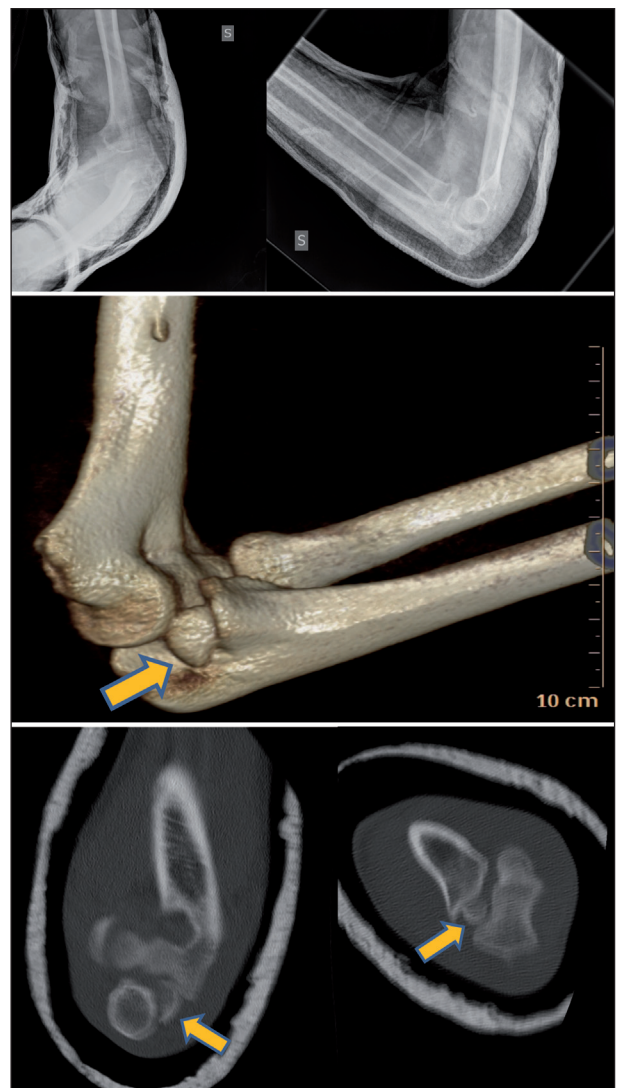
X-rays and 3D CT after reduction. Arrows show intra-articular fragment
